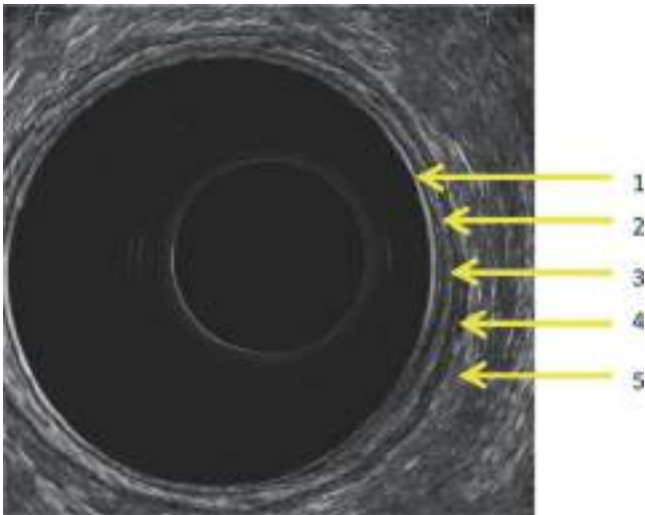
Endosonographic layers of the rectal wall. (1) Interphase of endoscopic balloon with mucosa. (2) Interphase of mucosa/submucosa. (3) Submucosa. (4) Muscularis propria. (5) Serosa and pericolic fat.
